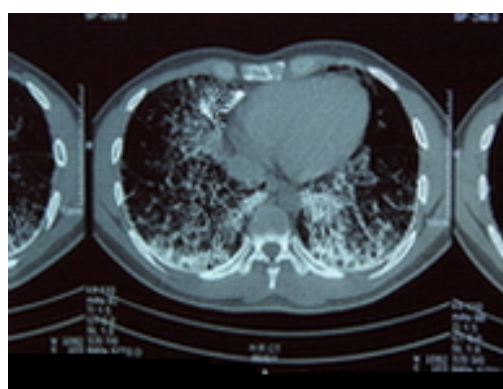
CT- Scan of patient
